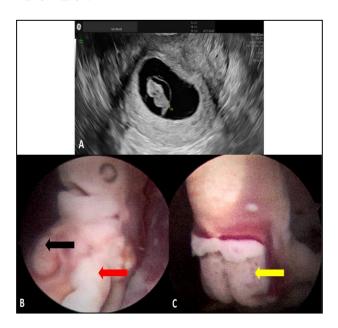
(A) Transvaginal ultrasound image of fetus.
